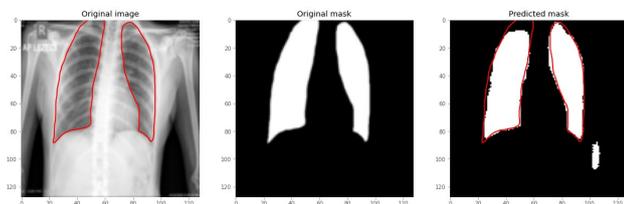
Lung segmentation using U-Net (worst case scenario): (a) the original chest X-ray image, (b) manually segmented mask, and (c) automatically segmented mask of the lung
